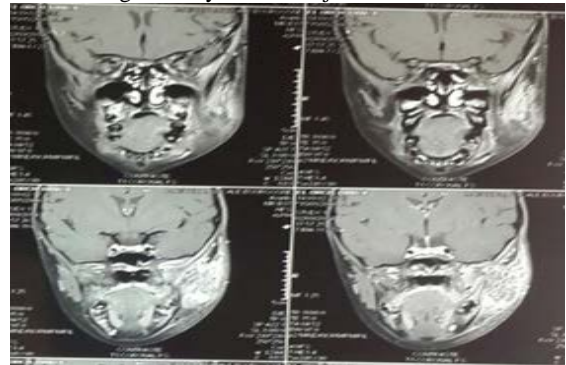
MRI image showing left parotid swelling.
